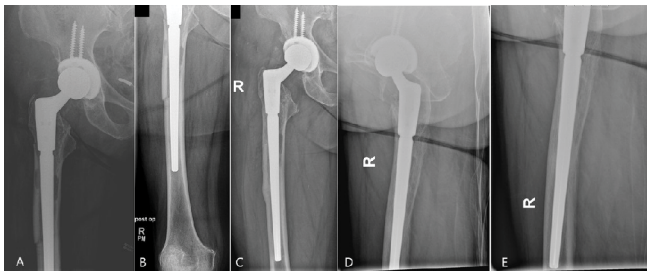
A-B: Postoperative radiographs of the right hip joint after prosthesis reimplantation; C-E: Six months later, the femur osteotomy is completely healed with no pseudarthrosis evidence.
